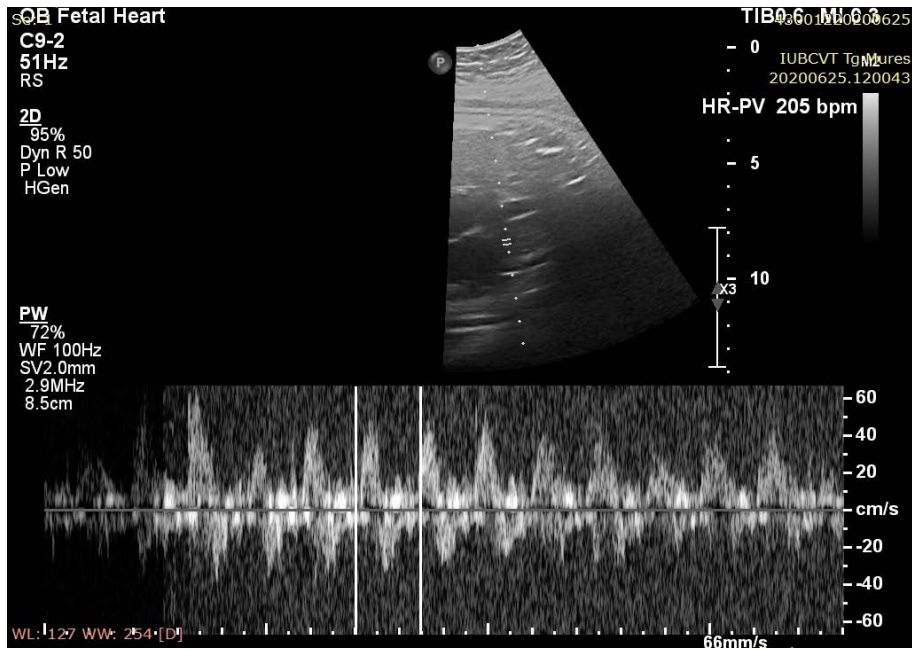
Pulsed Doppler echocardiogram from the fetus
